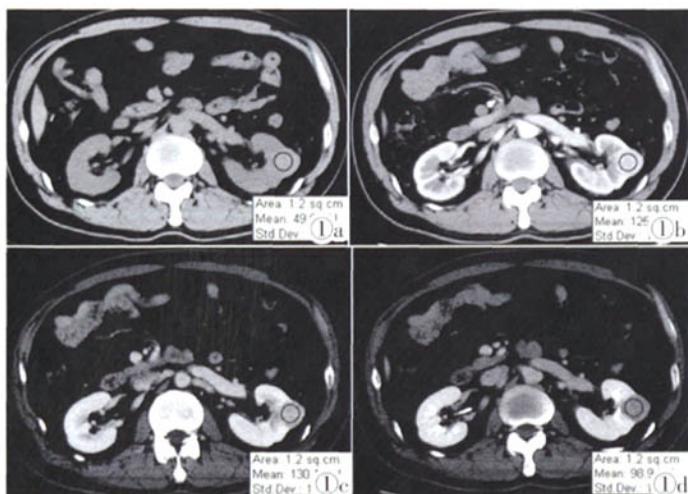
左肾微脂性血管平滑肌脂肪瘤。男,48 岁,体检发现左肾占位 20 余天。图 1a:CT 平扫;左肾均匀高密度占位;图 1b~1d 分别为增强后皮髓质期、肾实质期及分泌期图片,显示左肾占位显著均匀强化,实质期达高峰。
